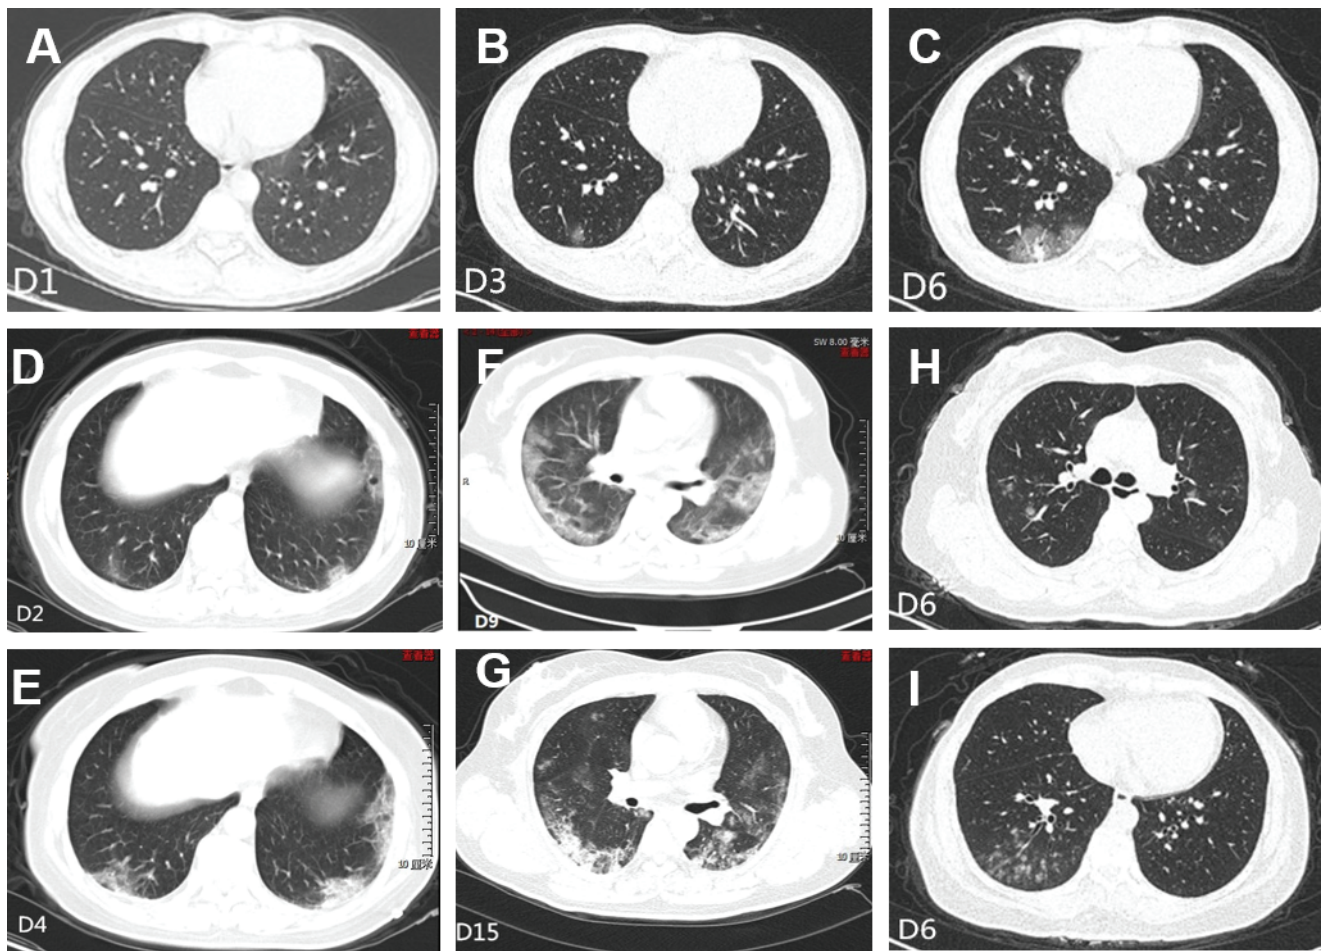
Transverse chest CT images from a 43-year-old male patient with COVID-19 showing no obvious pneumonia change on day 1 after illness (A), a mottling and ground-glass opacity in the right lower lobe on day 3 after illness (B), and multiple mottling and ground-glass opacity in the right upper and lower lobes on day 6 after illness (C). Transverse chest CT images from a 56-year-old female patient with COVID-19 showing bilateral, multiple, lobular mottling and ground-glass opacity on day 2 after illness onset (D) and extensively bilateral, lobular, ground-glass opacity on day 4 after illness onset (E). Transverse chest CT images from a 52-year-old female patient with COVID-19 showing extensively bilateral ground-glass opacity and subsegmental areas of consolidation on day 9 after illness onset (F) and bilaterally reduced, ground-glass opacity, and subsegmental areas of consolidation on day 15 after illness onset (G). Transverse chest CT images from a 66-year-old female non-COVID-19 patient showing multiple patchy and mottling shadows (H) and partial ground-glass opacity (I) on day 6 after illness onset. Abbreviation: COVID-19, coronavirus 2019; CT, computed tomography.
